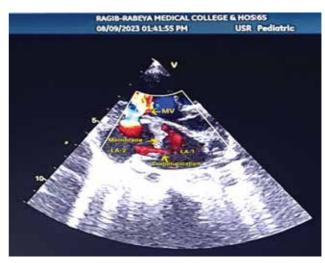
Modified 2D PLAX view with color doppler across the membrane, shows shunt across the fenestration in the membrane from LA-1 to LA-2 and also across mitral valve.
